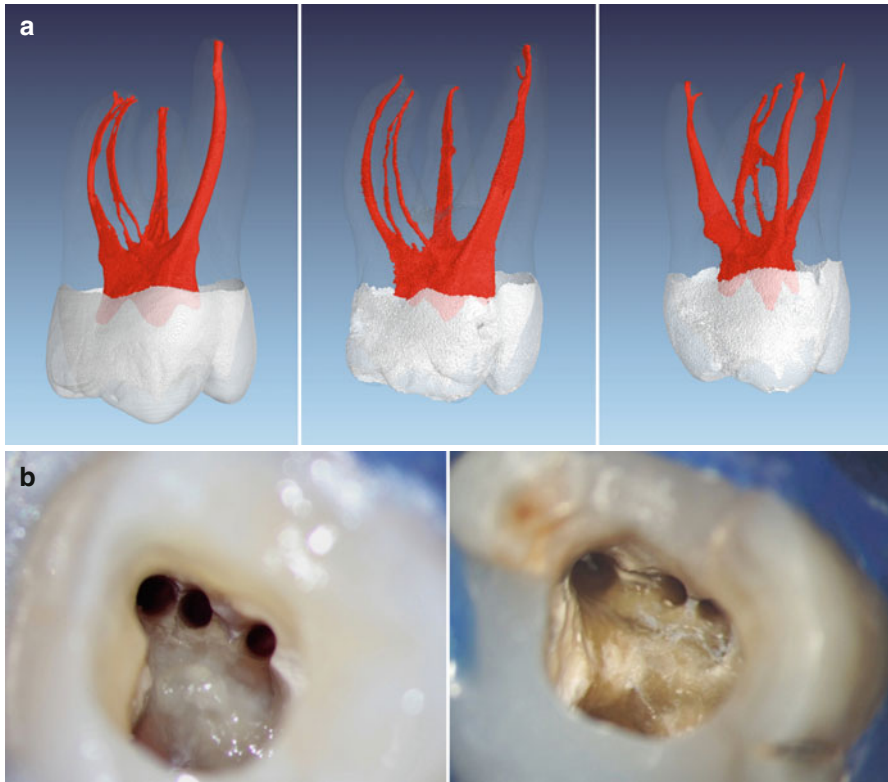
(a) Micro-computed tomography images of three extracted first maxillary molars with three mesiobuccal root canals. Note that two of the extracted teeth show MB2 and MB3 joining on their travel to the apex (*left and middle*), while one of the extracted teeth shows a separate portal of exit (*right*). (b) Two clinical examples showing the mesiobuccal aspect of access cavities after preparation of three mesiobuccal root canals with rotary instruments
